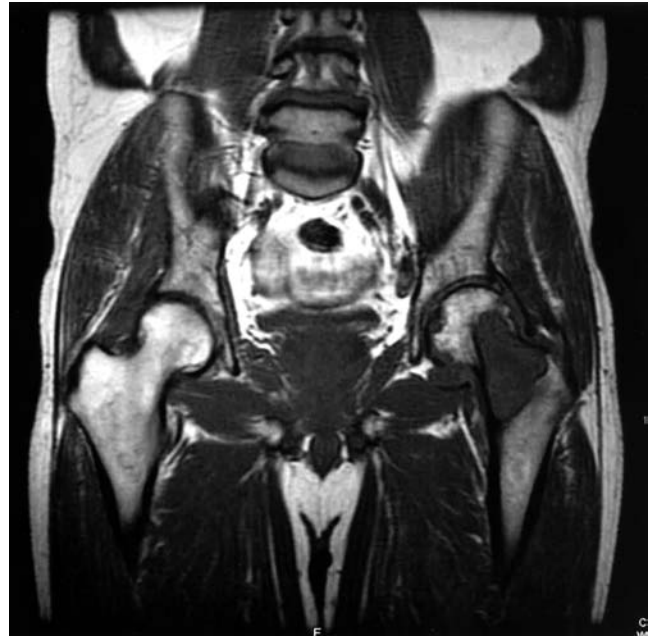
Coronal MRI of the pelvis shows a large lesion of the left femoral neck and head with uniform intermediate signal (coronal noncontrast T1 weighted image; TR/TE 500/9; 512 × 512; 1 NEX; 1.5 Tesla).
